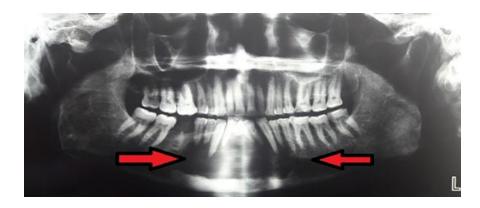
Panoramic radiograph showing multilocular radiolucency in the anterior mandible
